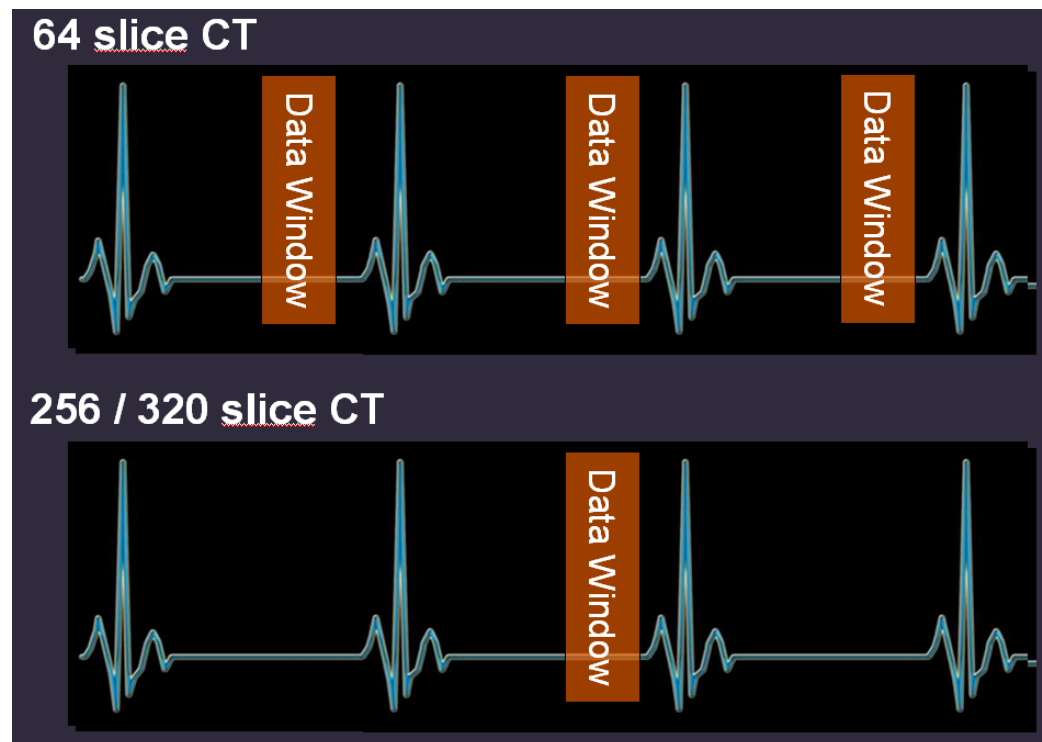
64-slice CTA, with a cranio-caudal coverage of 3.2 cm in a single rotation, requires image acquisition of the entire heart in multiple heart beats. State of the art 320-row and 256-slice CTA, with a cranio-caudal coverage of 12.8 and 16 cm, respectively, allows image acquisition of the entire heart in a single heart beat. Reproduced with permission from Dr. Achenbach. Abbreviations: CT: computed tomography.
